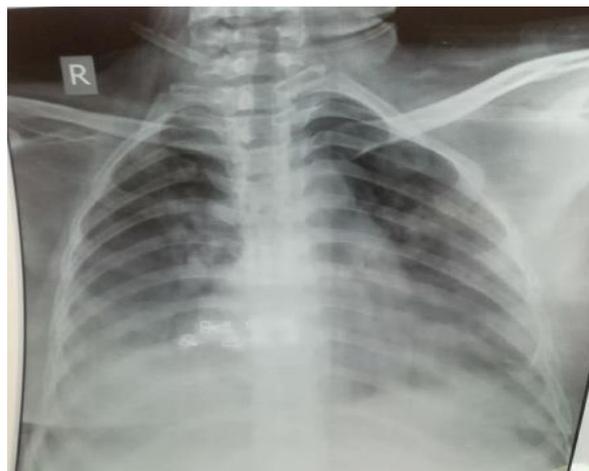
Chest X-Ray (shielded) of 26yr third trimester pregnant female (7 month), on day 0 (on day of admission) showing bilateral consolidation, moderate-severe with periphery and lower lobes predominance.
